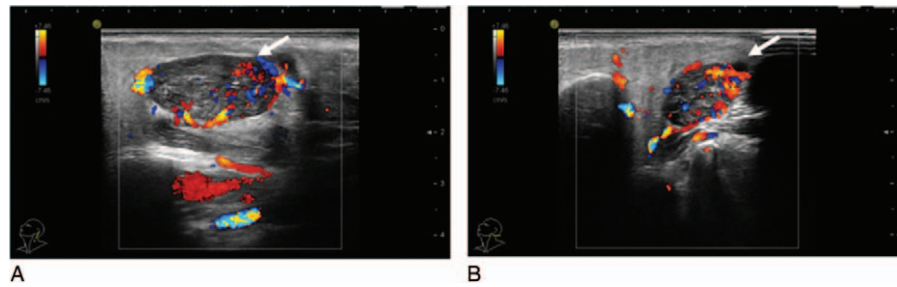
Ultrasonic examination before ablation. Ultrasonic examination showed an oval hypoechoic nodule in posterior-inferior area of left parotid gland, with clear border and complete capsule and a high flow velocity in Color Doppler Flow Imaging. (A) Cross-section images; (B) longitudinal section images.
